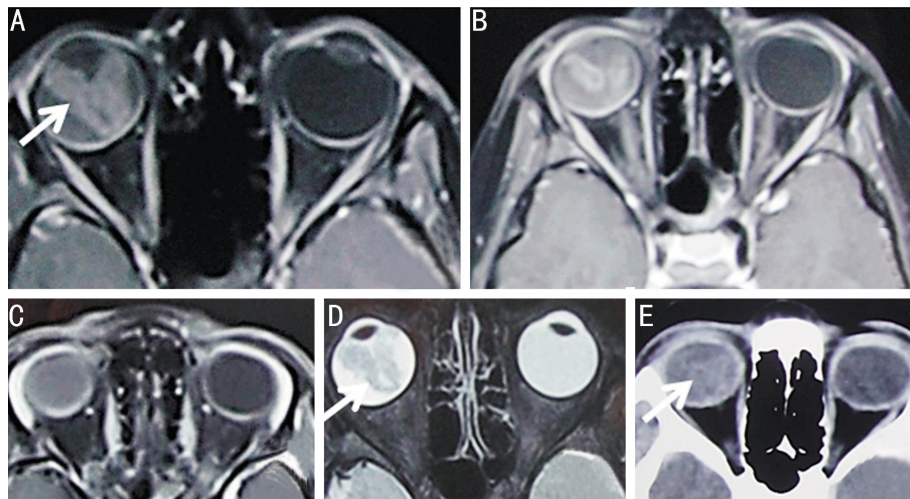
A girl presented with leucocoria in the right eye. Intraocular findings on MRI and CT scans of the orbits at the time of presentation. Axial contrast-enhanced T1-weighted (A-C) and T2-weighted (D) MRI showed a bullous retinal detachment and thickened retinal leaves (arrows), with no definite mass. (E) CT scan of orbits (axial cut) to show the absence of intraocular calcification (arrow).
